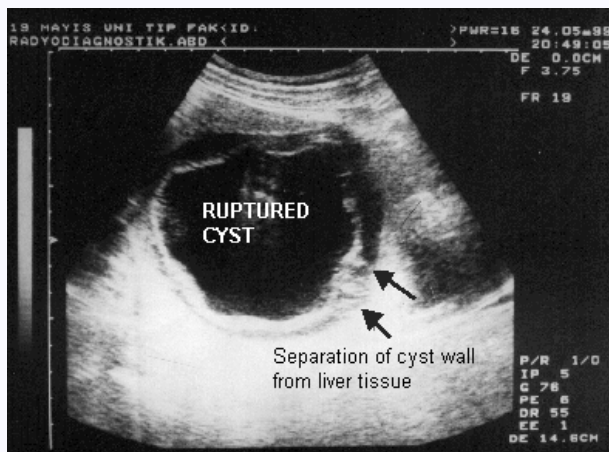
Ultrasonogram of the ruptured hydatid cyst in the left hepatic lobe.
